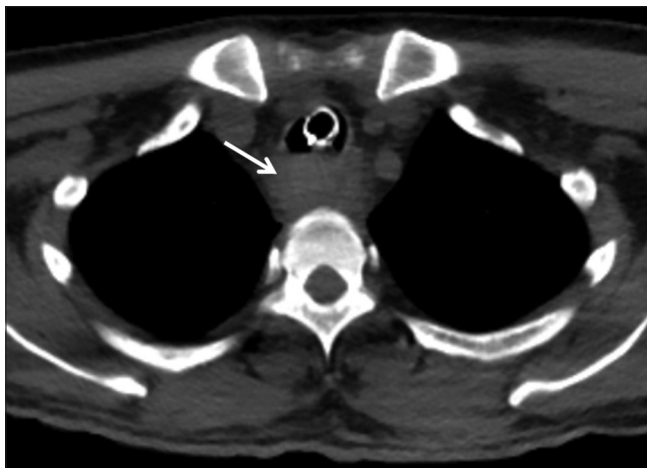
Axial non-enhanced CT chest showing hyperdense hematoma in and around the esophagus (arrow)
